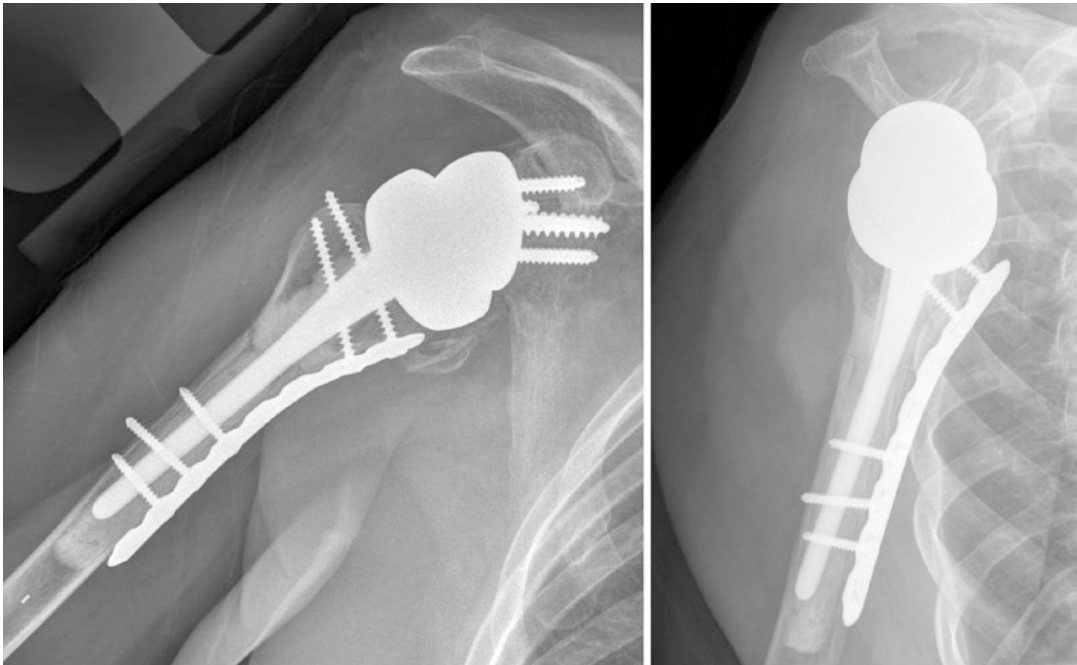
Anteroposterior and lateral radiographs demonstrating graft-to-host union, adequate fixation, and stability of the humeral component with good restoration of proximal arm anatomy following a reverse APC
